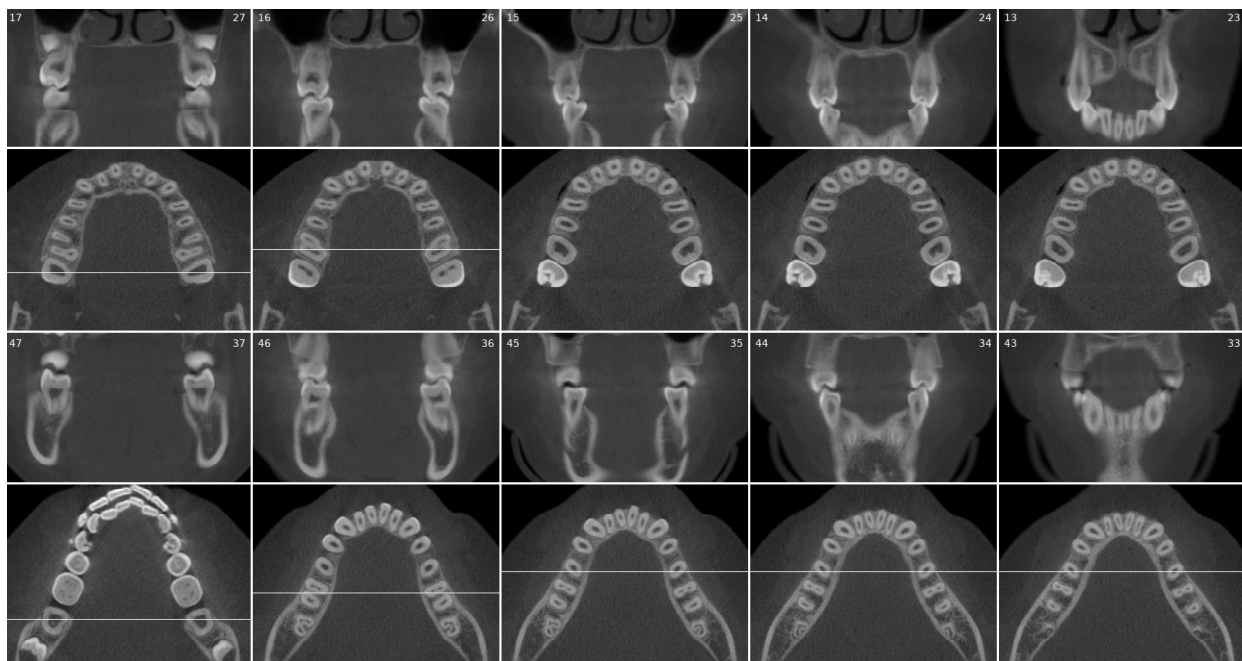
CBCT-based multimodal digital profiling of the dentition and maxillofacial structures. A panel of coronal CBCT slices with corresponding axial views, exported from Diagnocat™ (DGNCT LLC, Miami, FL, USA), is arranged across the maxillary and mandibular arches (indices correspond to FDI tooth numbering). The images document tooth position, root and canal morphology, sinus and fossa relationships, and eruptive status—features that are highly individualized and valuable for objective matching of ante-mortem and post-mortem dental records during human identification. The horizontal and vertical lines visible in the image represent the reference crosshair and slice navigation guides of the CBCT viewing software at the time of screenshot capture and are not anatomical or measurement indicators.
